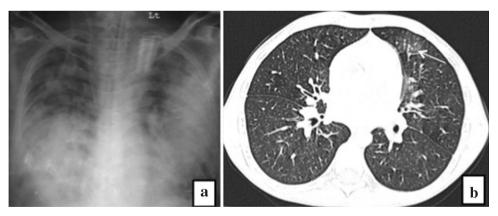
a Chest radiograph shows the presence of lobar and patchy consolidation in both lungs in a patient with Legionella pneumonia. b Chest CT in a patient with *Mycoplasma pneumonia* shows the presence of patchy areas of GGOs in lingula (*white arrow*)
